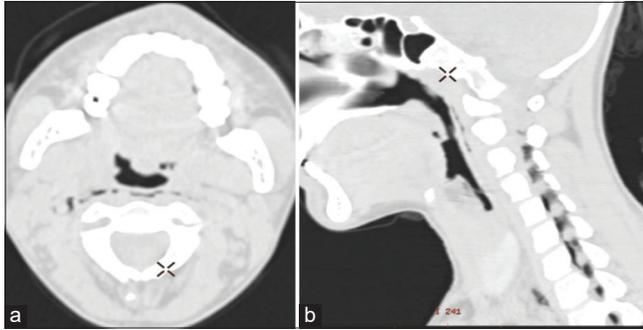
(a) Axial computed tomography (CT) section at the level of oropharynx showing air in the pre-vertebral space. (b) Sagittal reformatted CT section showing air in the cervical segment of spinal canal.
